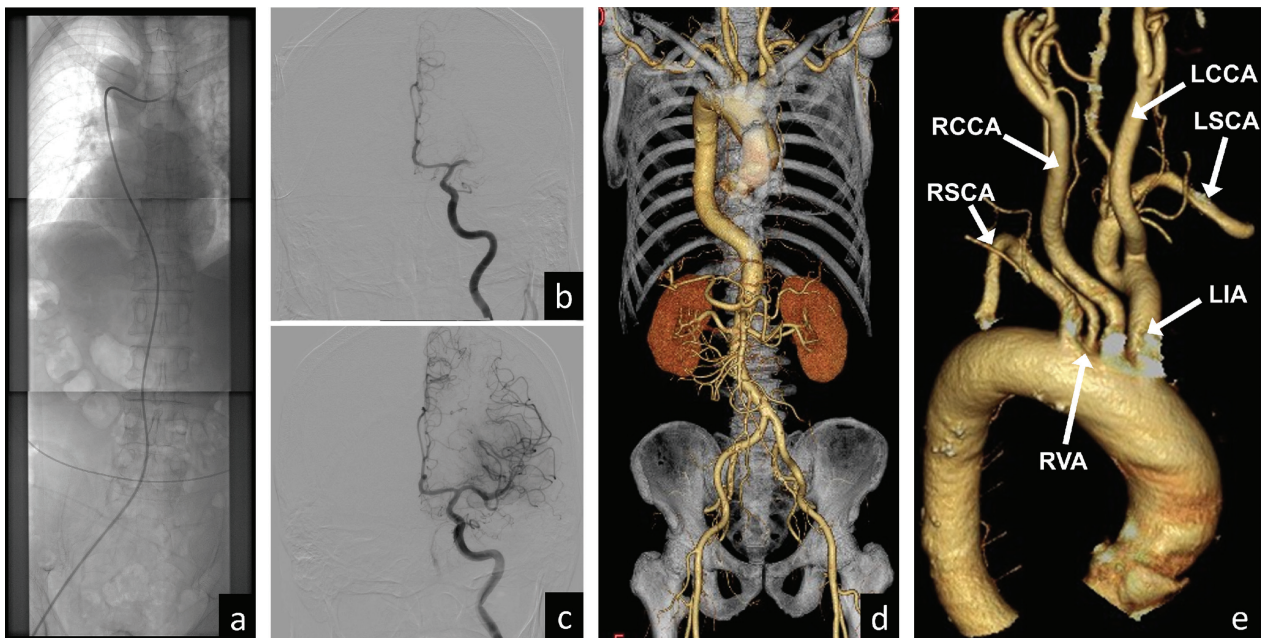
Catheter navigation, thrombectomy, and CT angiography. (a) Balloon guiding catheter navigation on anteroposterior images. (b and c) Anteroposterior internal carotid artery injection (b) before and (c) after the thrombectomy. Final injection shows TICI 2B recanalization. (d and e) CT angiography on the day after procedure shows right-sided arch with mirror-image branching pattern. Innominate artery is on the left side and left common carotid artery arises from left innominate artery. Right vertebral artery directly arises from aortic arch. CT: computed tomography, LCCA: left common carotid artery, LIA: left innominate artery, LSCA: left subclavian artery, RCCA: right common carotid artery, RSCA: right subclavian artery, RVA: right vertebral artery, TICI: thrombolysis in cerebral infarction.
